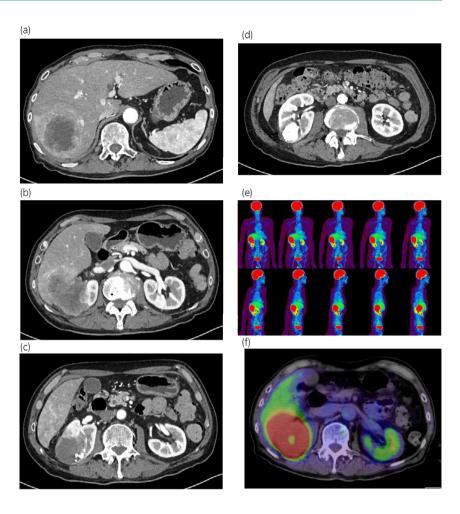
A CT scan and FDG-PET/CT were performed 1 month after the CT shown in Figure 1. There was rapid growth of the right renal tumor and progression to hepatic invasion (a–d). FDG-PET/CT did not reveal metastasis (e, f).
